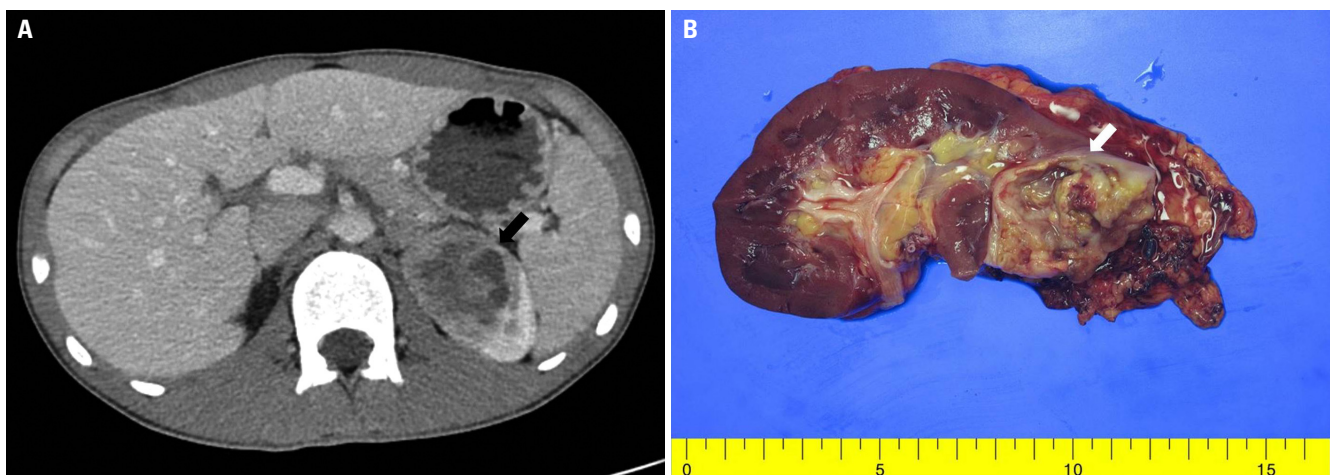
Gross findings of *ALK* rearrangement-associated renal cell carcinoma. (A) A well-demarcated, solid cystic mass (arrow) at the upper pole of the left kidney is observed on abdominal computed tomography. (B) The mass (arrow) is yellow-to-grey, involving the renal medulla and cortex.
